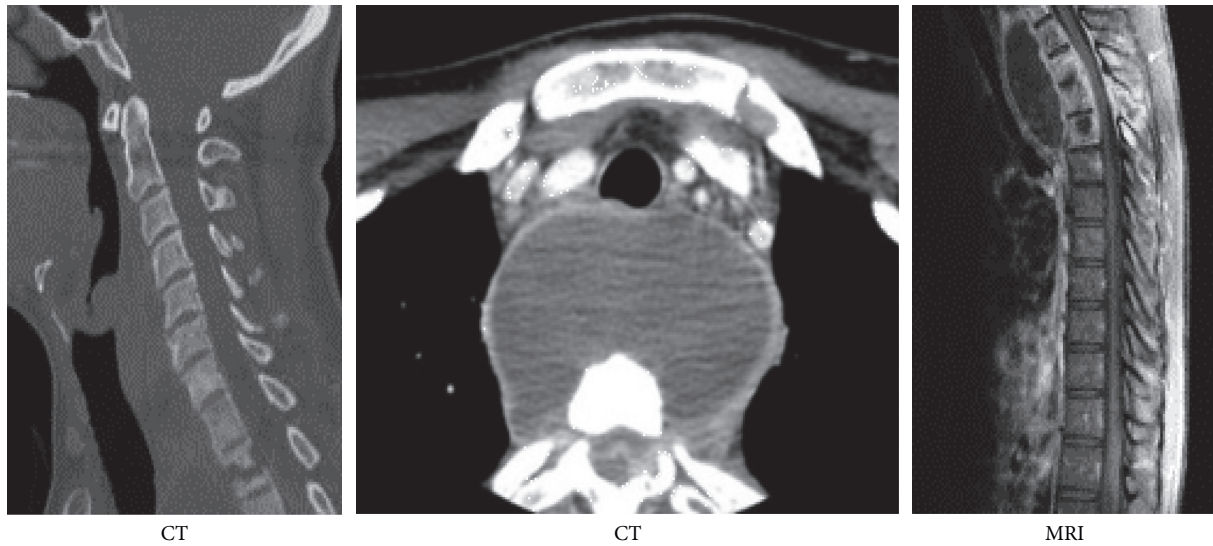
MRI and CT imaging examinations of AIDS patients with spinal tuberculosis.
